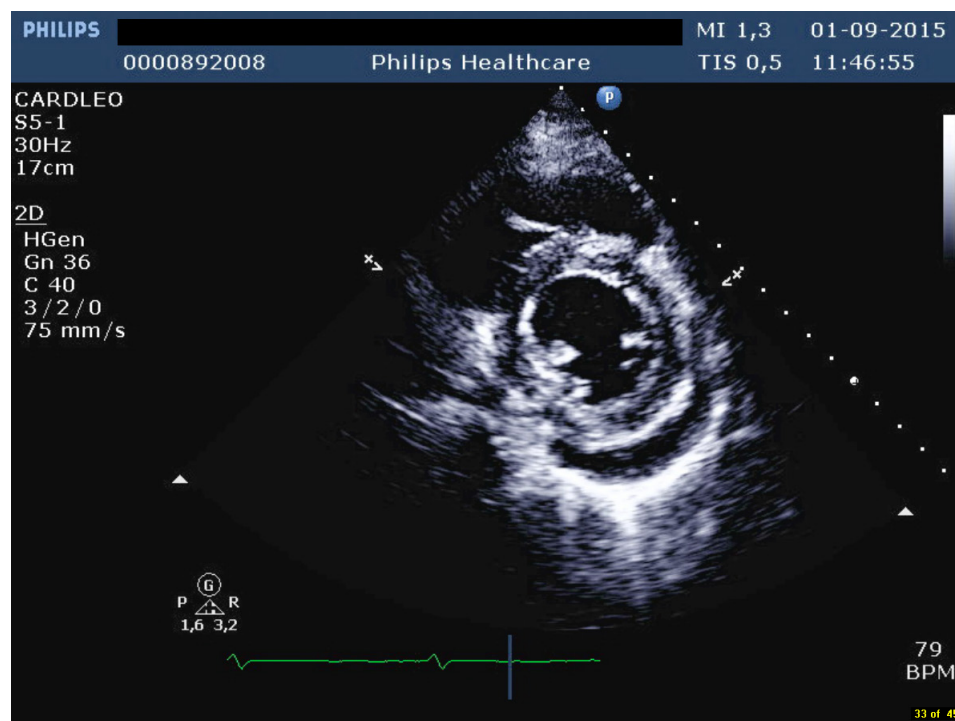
Control echocardiogram performed two weeks after treatment initiation showing thickening of pericardial layers and moderate effusion, septal bounce and increased respiratory variability of the transtricuspid flow.
